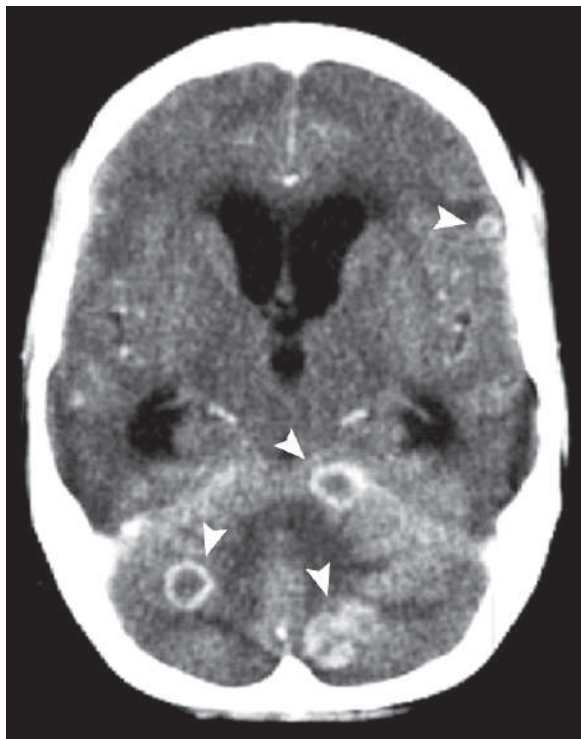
Axial postcontrast CT image show multiple tuberculous abscesses in a patient with disseminated TB (*arrowheads*)
